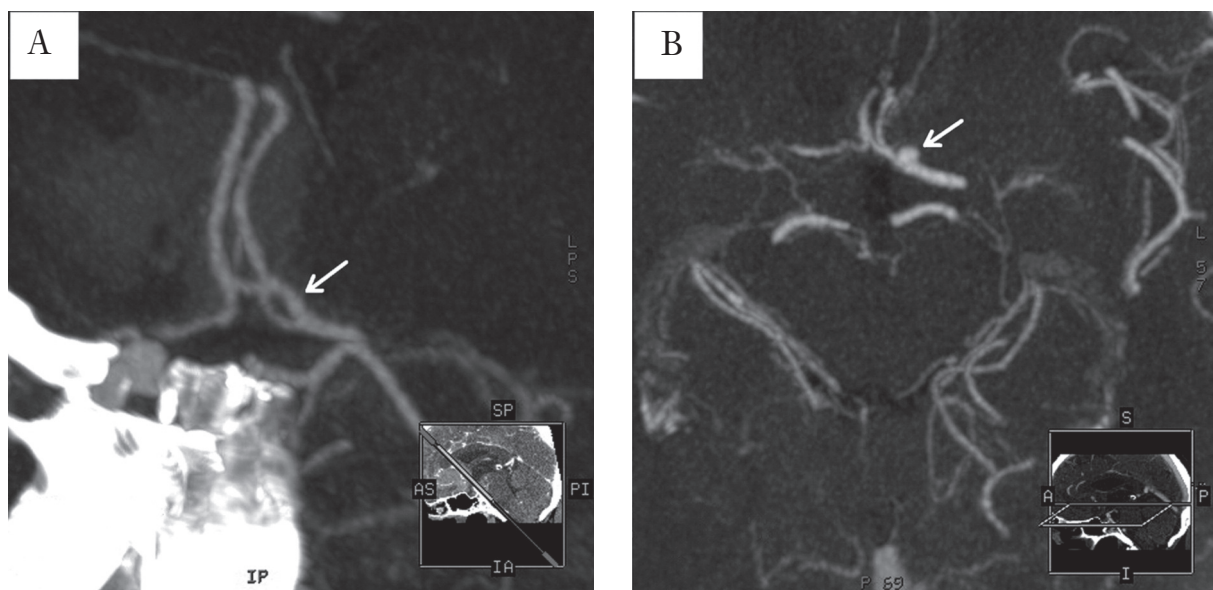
CT angiography – MIP reconstruction. A) anterior cerebral artery fenestration (arrow) and subarachnoid haemorrhage. B) CT angiography after three weeks shows aneurysm at the place of fenestration (arrow)
